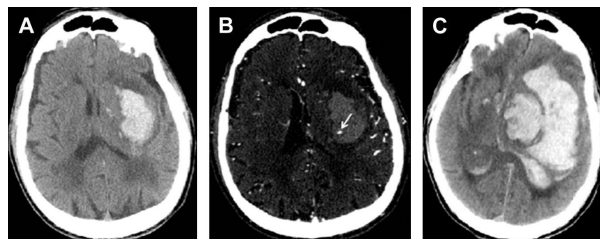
(A) Left deep ICH on NCCT, with baseline volume of 45 mL; (B) CTA showing presence of spot sign (arrow); (C) follow-up NCCT at 19 hours showed significant hematoma growth to a volume of 192 mL with severe midline shift and massive intraventricular extension [3]
